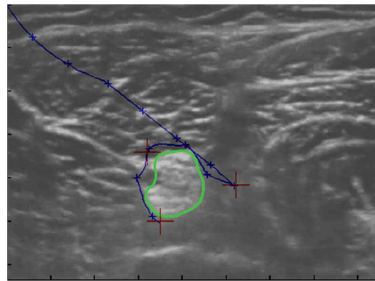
Trajectory generation in the ultrasound image: the segmented nerve block (green line), red crosses represent the anaesthetic agent successive delivering targets.
